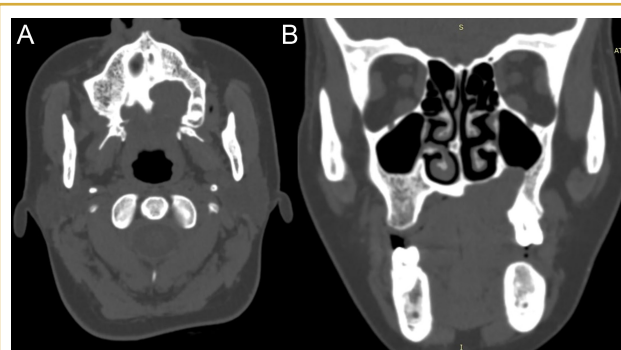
A, B. (A) Axial computed tomography (CT) image revealed a hypodense area in the posterior maxilla. (B) Coronal CT image showed perforation of palatal cortical bone and floor of the left maxillary sinus.
